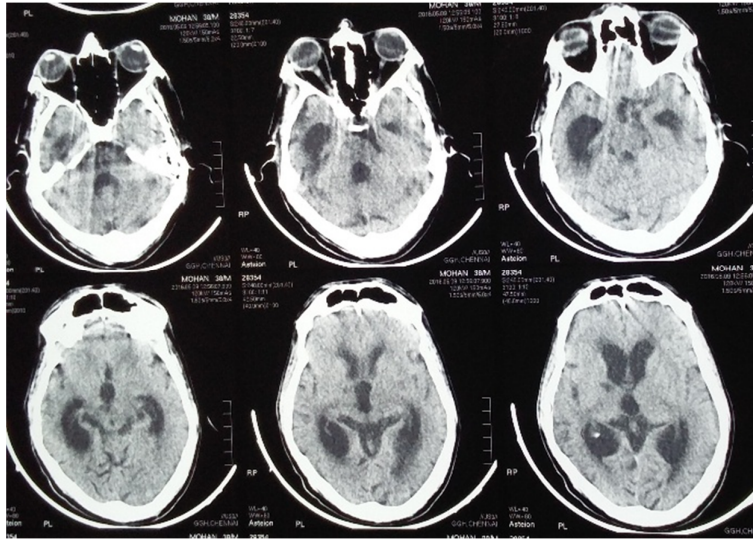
CT brain plain showing TBM communicating hydrocephalus.
